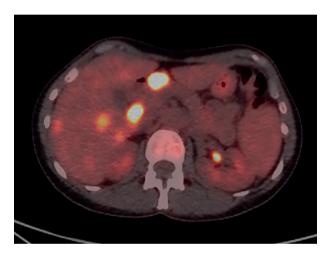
PNs at the PET-CT with a high contrast uptake (SUV max 10.9).
